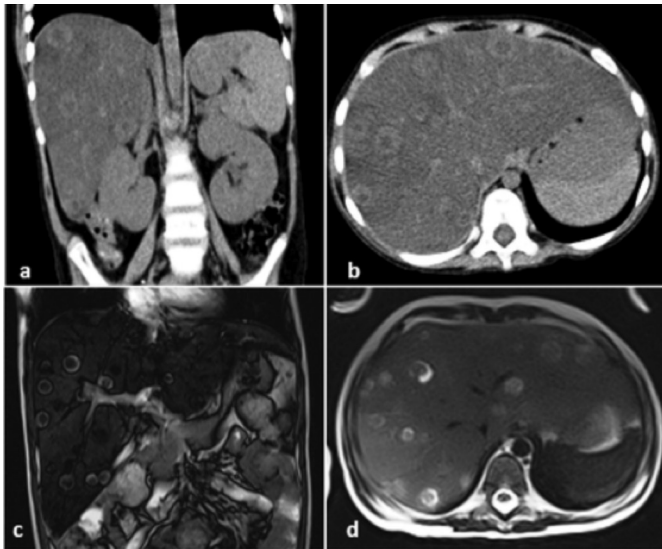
Coronal and axial computed tomography images (a, b); coronal and axial magnetic resonance images of circumscribed typical hepatic *Candida* lesions (c, d).
